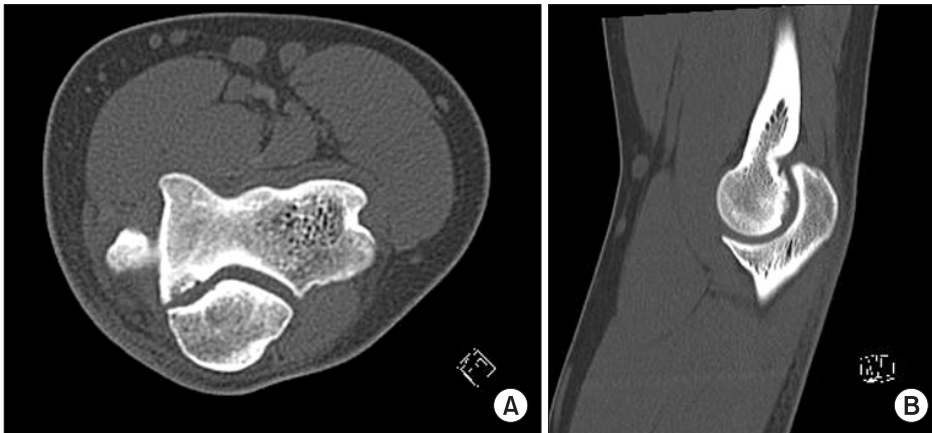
Computed tomography scan of left elbow showing radiolucent lesion in trochlea. (A) Axial reconstruction of noncontrast CT scan of the elbow demonstrates an osseous defect. (B) OCD lesion of the medial trochlea is located between two and five o'clock position as seen on sagittal image.
